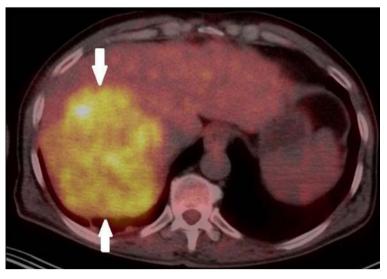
A hypermetabolic lesion with heterogeneous increased FDG uptake was observed in the liver.
